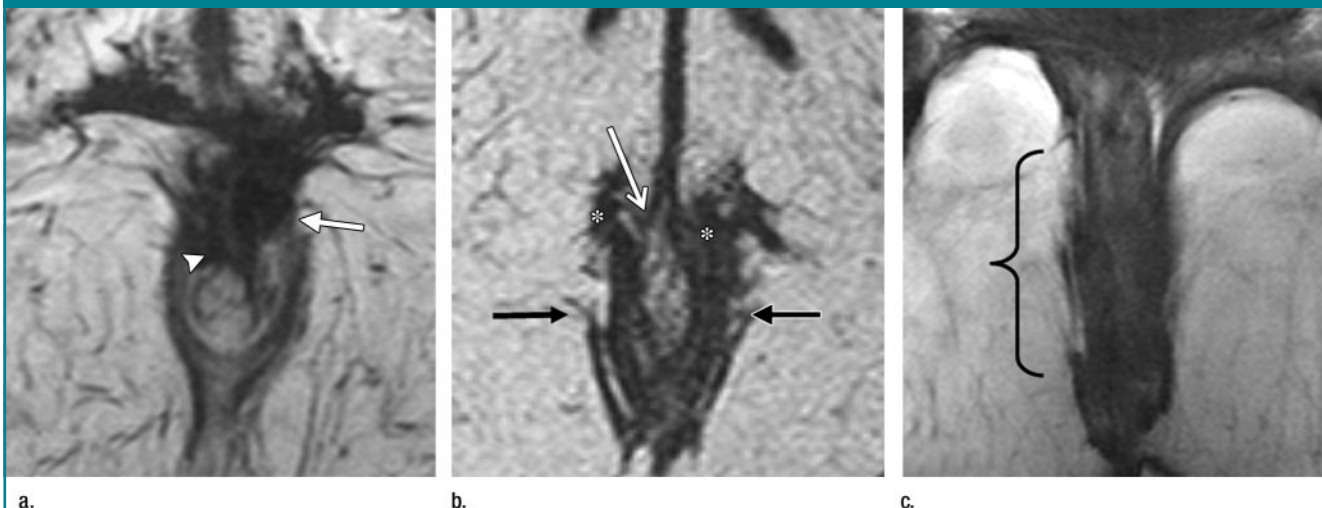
Static MR images in two patients (one 54-year-old woman [a] and one 33-year-old woman [b, c]) with both anal incontinence and POP. (a) Axial balanced fast-field echo image (9/4) of anal sphincter complex. Arrow = scarring of external anal sphincter, arrowhead = scarring of internal anal sphincter. (b) Axial and (c) coronal MR images obtained with the same sequence as a show fraying and an anterior defect (*) of the internal anal sphincter with bulging mucosa (white arrow), plus a defect of the external anal sphincter (black arrows). The brace in c indicates a defect of the deep part of the external anal sphincter as well as the puborectalis muscle.
